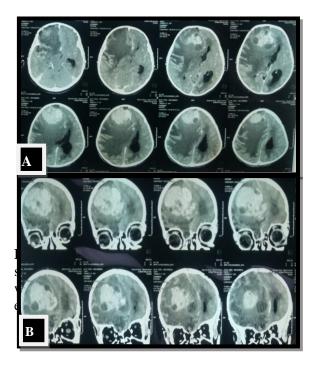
Contrasted Brain CT scan shows an intra-axial heterogenous mass within the right frontal lobe with surrounding extensive vasogenic edema and midline shift. A: Axial cuts, B: Coronal cuts. Two days later, a brain magnetic resonance imaging (MRI) was performed. It demonstrated an intra-axial hyperintense mass within the right frontal lobe with a mixture of cystic and solid components and calcified foci, with severe suurounding vasogenic edema and midline shift about 1.6 cm to the left side and secondary non communicating hydrocephalus (Figure 2)
